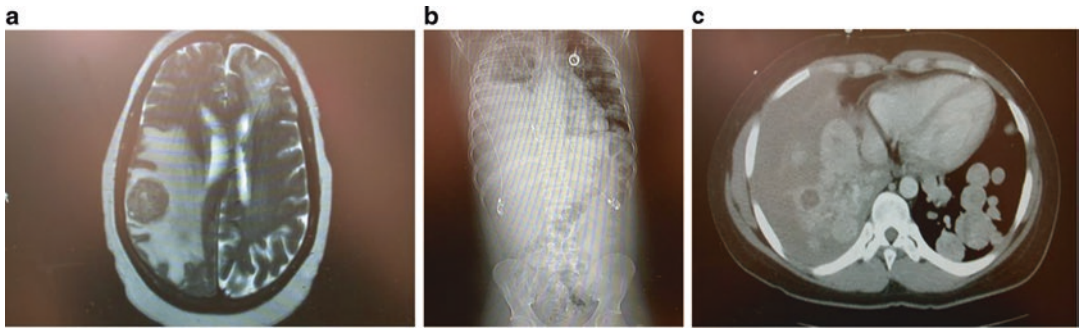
(a) An axial T2-weighted MRI of the brain depicting a right supratentorial mass with associated edema. (b) A plain film X-ray depicting an ipsilateral
